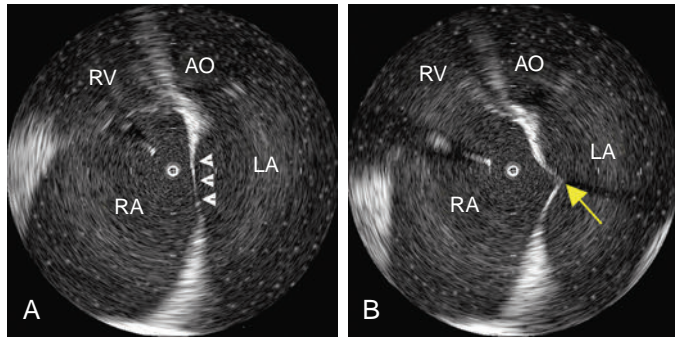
Intracardiac Echocardiography (ICE)-Guided Transseptal Puncture Using the Ultra-ICE Catheter. These ICE images are obtained with the transducer placed in the right atrium (RA). (A) The RA, fossa ovalis (arrowheads), left atrium (LA), and aorta (AO) are visualized. (B) The transseptal needle is properly positioned, with tenting (yellow arrow) against the mid-interatrial septum at the fossa ovalis. RV, Right ventricle.
